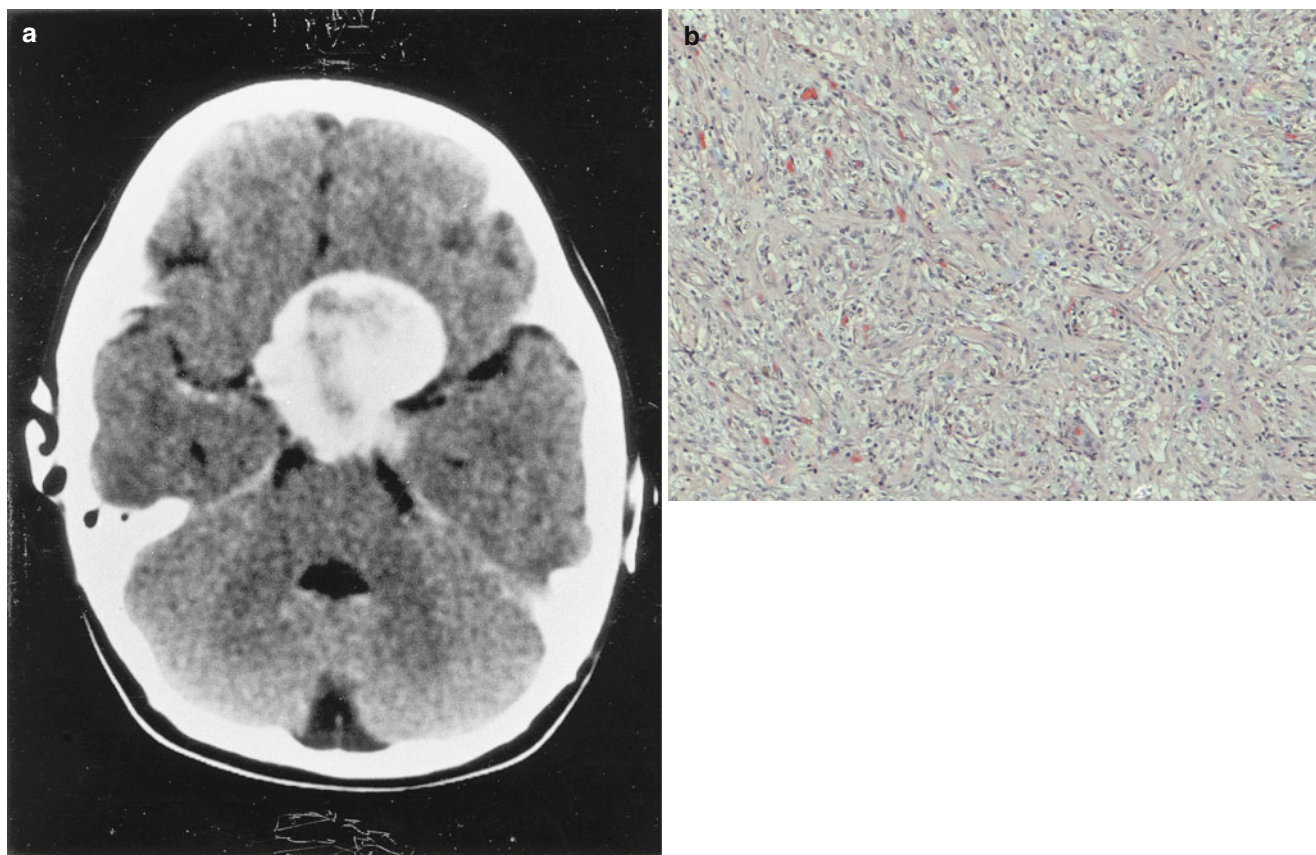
Astrocytoma. Five-month-old female with intermittent vertical nystagmus. (a) CT scan of the head reveals a lobulated, midline mass occupying the suprasellar cistern and involving the optic chiasm
